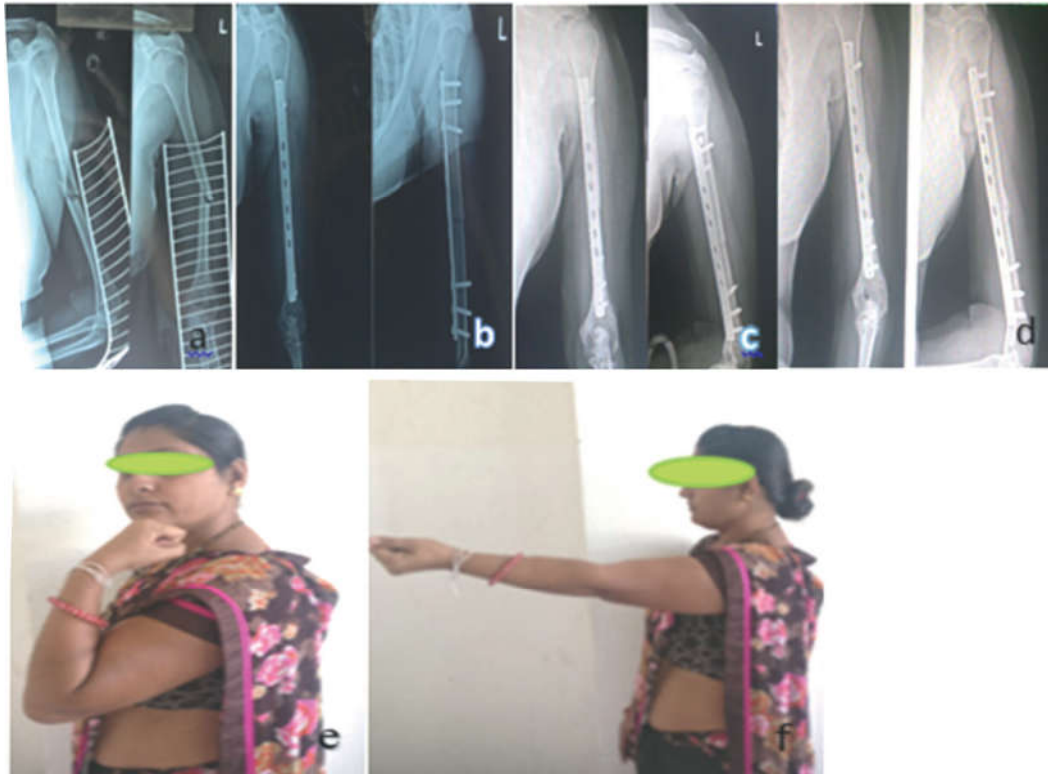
A 29-year-old female, trauma due to road traffic accident was treated with the MIPO technique. a Preoperative radiograph shows a mid-third humeral shaft fracture (OTA 12-A2). b post operative, c 3 months follow up, d 12 months follow up radiographs. e & f clinical images performing function at elbow joint.
